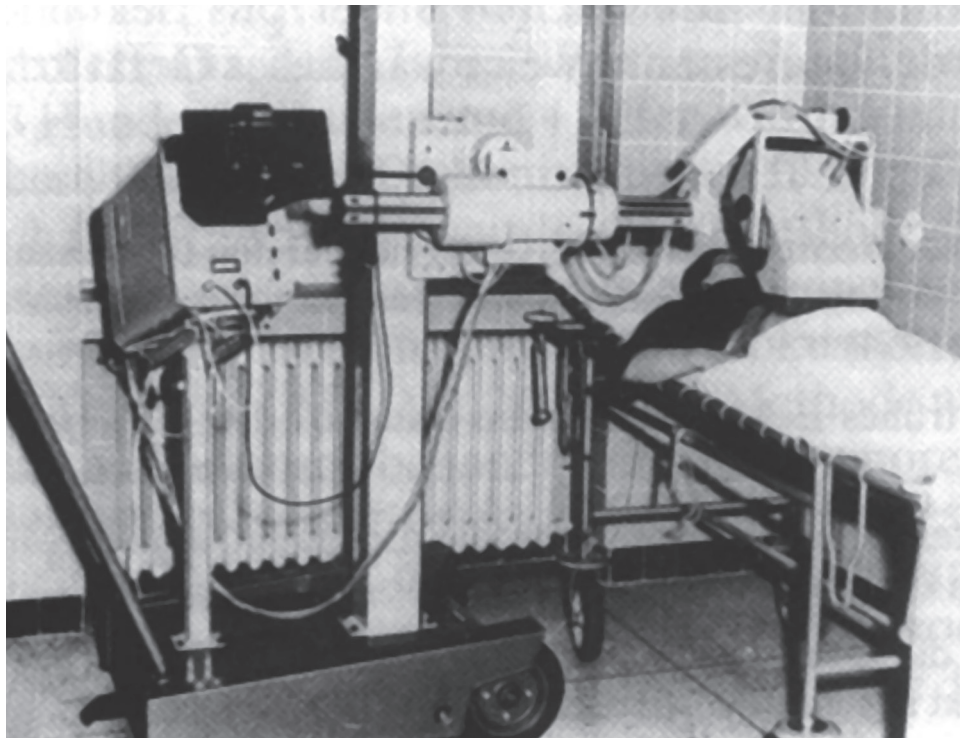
First real-time scanner (Videoson) with bulky transducer for B-mode ultrasound examination of the abdomen.
